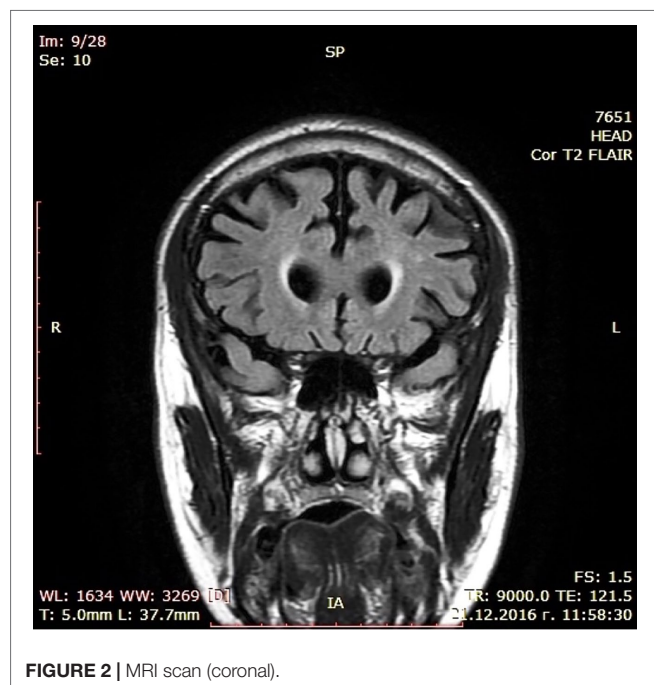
MRI scan (coronal).
